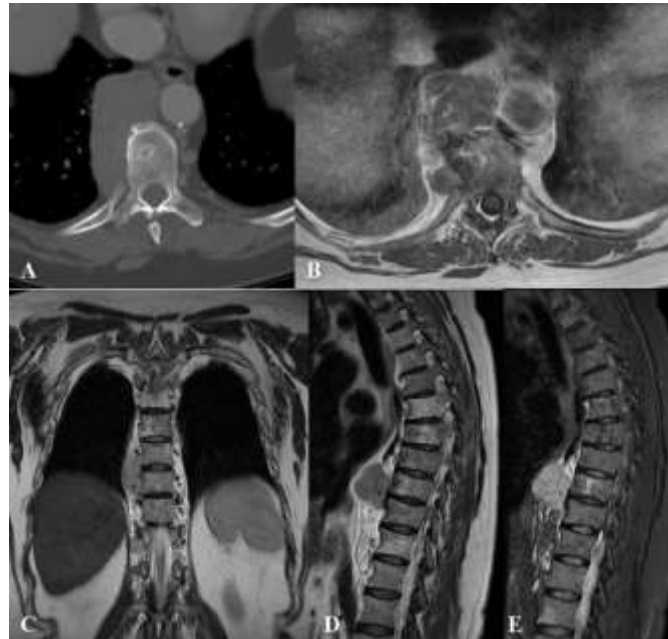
Non-Hodgkin lymphoma paravertebral lesion in a 68 years old female patient. Axial CT scan (A), hypodense expansive mass with significant contrast enhancement in the right paravertebral space, no bone erosion is found. MRI - axial T1w after contrast injection (B), coronal T2w (C), sagittal T2w (D) and STIR (E) – of the polylobular lesion in the paravertebral and right retrocrural space of D8-D10 tract, low signal at T1w images with homogeneous enhancement after intravenous gadolinium administration, this mass occupies the costovertebral space but does not show signs of erosion of the contiguous vertebral bodies.
